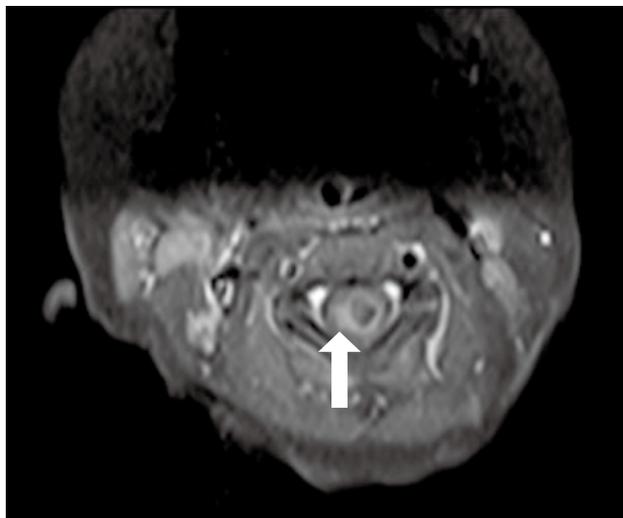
A contrast T1-weighted axial magnetic resonance image shows heterogeneous contrast enhancement of the cord lesion, which is purely intramedullary (arrow).
